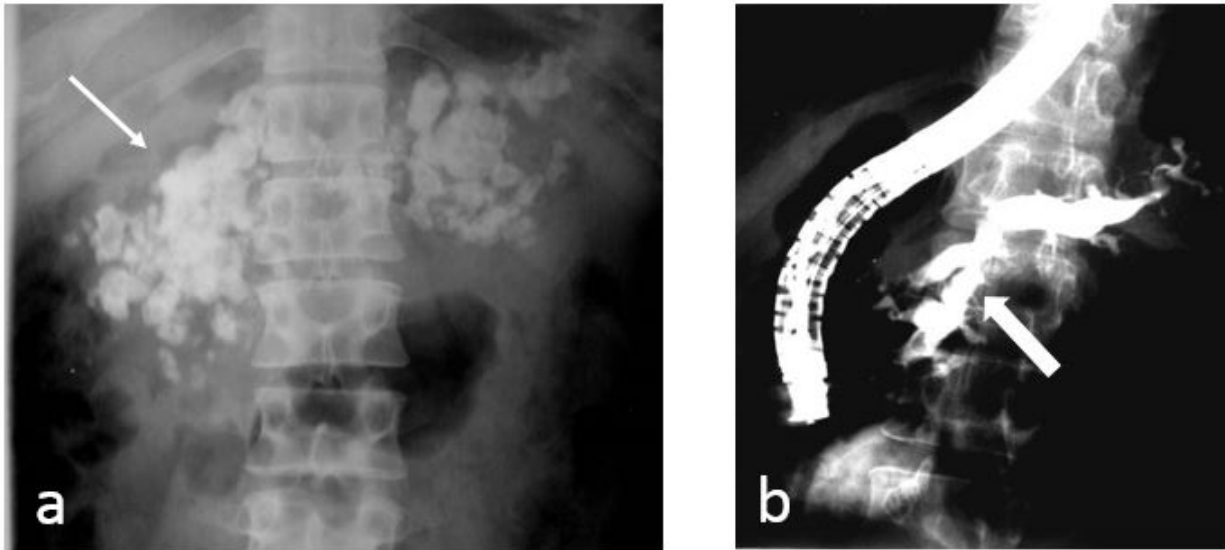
Abdominal radiograph in AP projection (a) shows multiple well defined calcific opacities (thin arrow) seen along the expected course of pancreas on either sides of spine suggestive of pancreatic calcification. ERCP image of a different patient (b) shows dilated and tortuous MPD and its side branches (thick arrow). These findings are suggestive of chronic pancreatitis.
